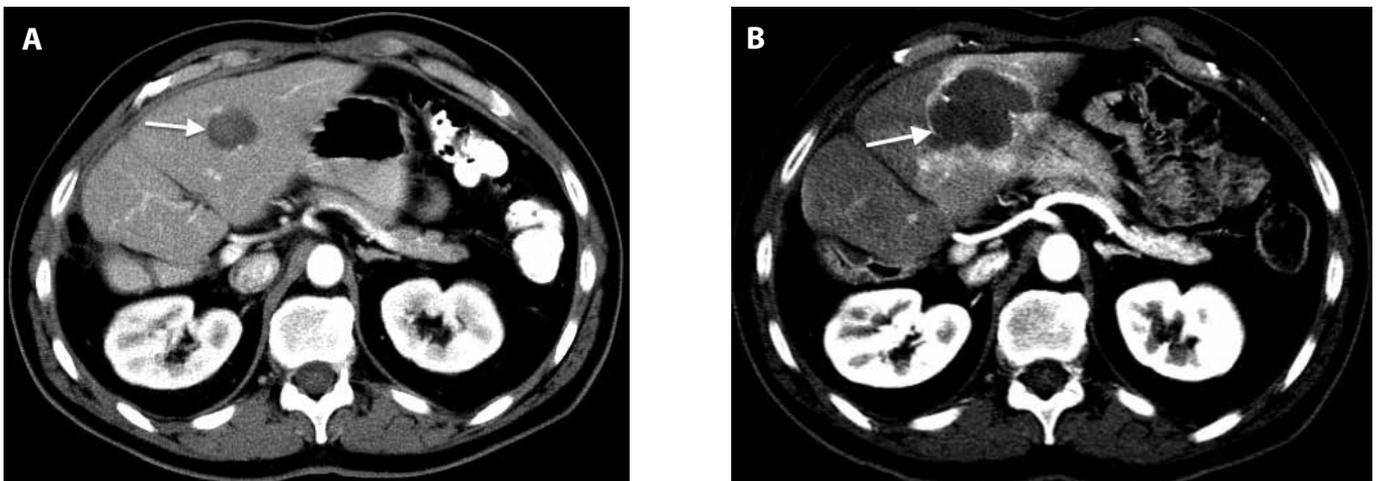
a) CT image before treatment; b) CT image after the treatment that shows a complete ablation
